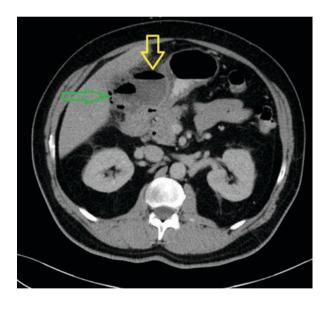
A CT scan demonstrating emphysematous cholecystitis in a 52-yearold man who presented with a 10-day history of biliary pain, fevers and night sweats
